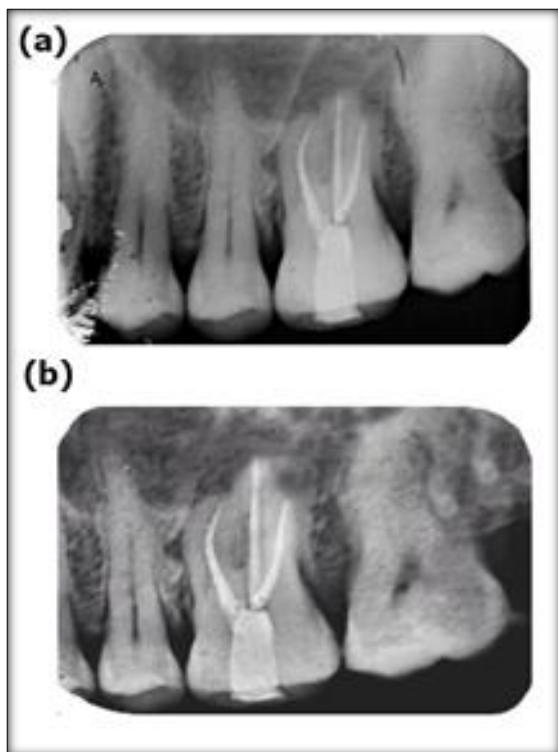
Follow up radiograph (a) at months (b) at 12 months
